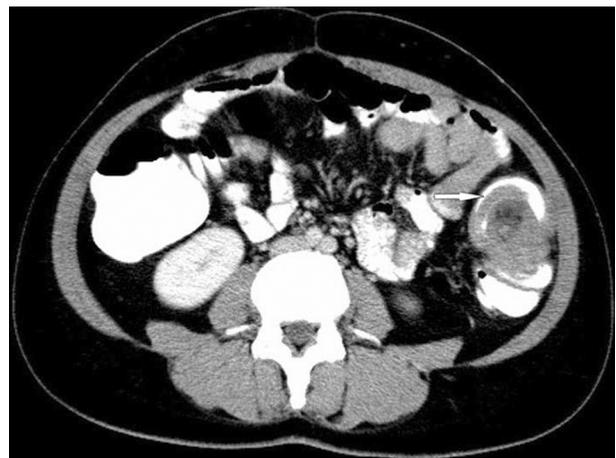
Computed tomographic scan demonstrating the target sign in a colo-colonic intussusception
